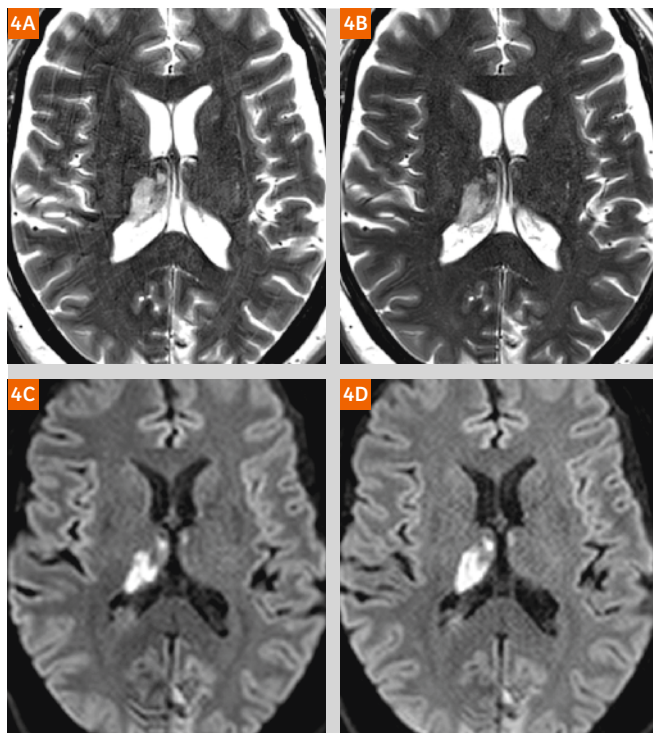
Thalamic infarct, (4A, B) T2-weighted TSE and (4C, D) diffusion-weighted ss-EPI scans. (4A, C) Conventional acquisition compared to (4B, D) SMS, the T2-weighted scan with an acceleration factor of three and the DWI with a factor of two. Note the ghosting and image degradation on the conventional T2-weighted scan due to the longer acquisition time. The SMS T2-weighted scan in this instance is superior and the SMS DWI scan equivalent in terms of image quality to the scans acquired in a conventional fashion.
